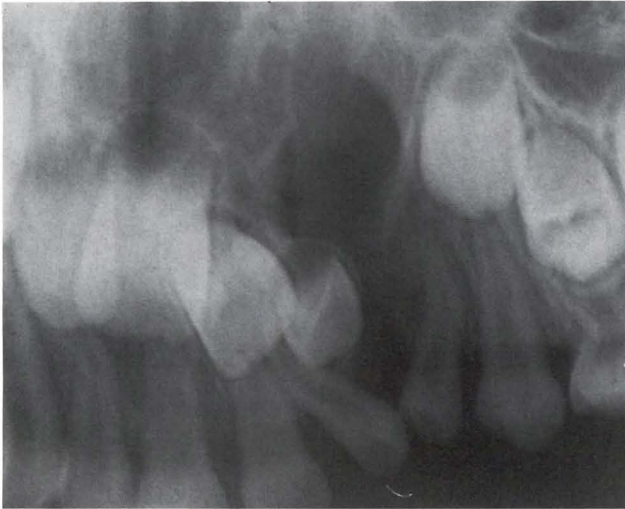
Panoramic radiograph (detail) of a patient with unilateral cleft (on the left side) presenting a primary supernumerary maxillary lateral incisor.
